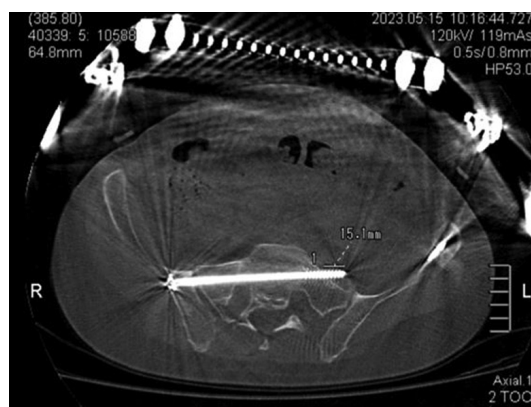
CT section shows the screw protruding on the anterior surface of the sacrum
